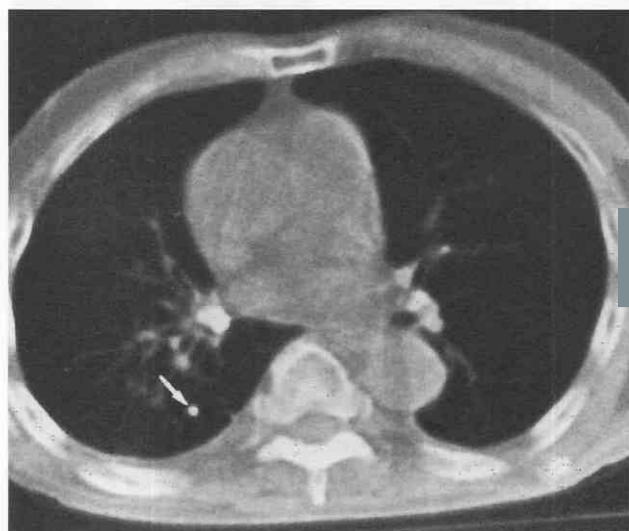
Ranke's complex. CT image shows the calcified parenchymal scar (Ghon's lesion) (arrow) and the calcified hilar nodes representing healed regional lymphatic involvement from the initial tuberculosis infection.
